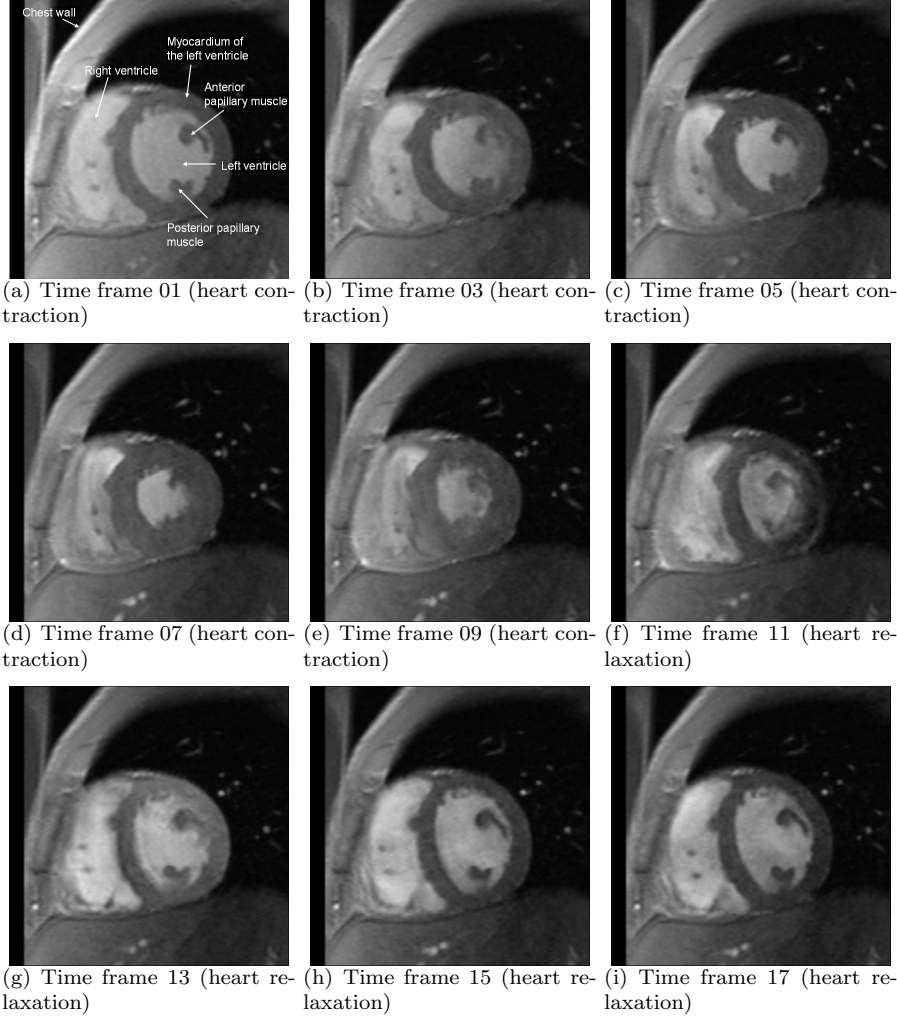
Example of cardiac MR images – dynamic CINE series of the heart in short axes (see [7], pages 415-418). A slice corresponding to the mid-cavity part of the ventricle during the cardiac cycle. Time frame 01 corresponds to the end-diastole (maximal ventricle volume), time frame 09 to the end-systole (minimal ventricle volume). Total number of images from single examination exceeds 100. The segmentation procedure has to be proceeded in all the images. For anatomical details see [8], pages 61-83.*
